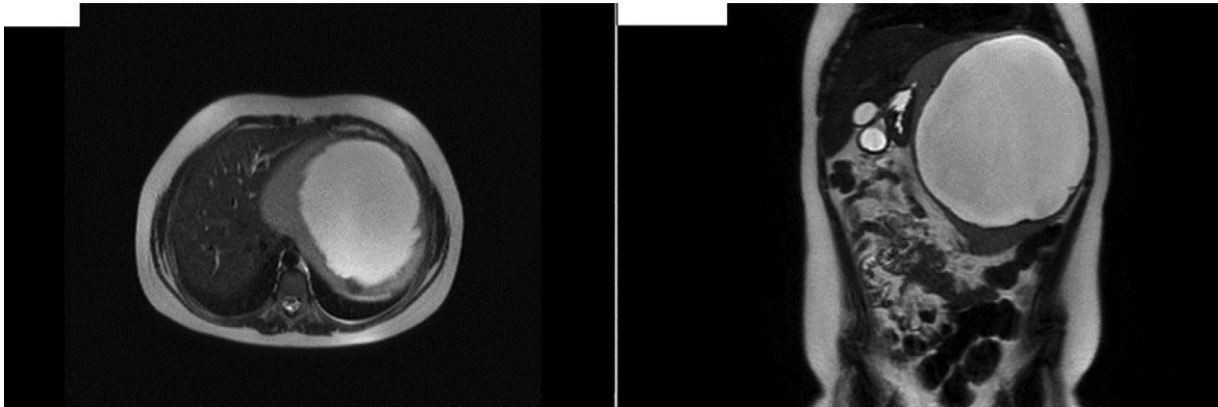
Axial (A) and coronal (B) magnetic resonance imaging of the child abdomen, showing splenomegaly ($20 \times 15 \times 16$ cm) with a polylobulated well-defined cystic mass ($16.8 \times 15 \times 15.5$ cm) with homogeneous fluid contents, hypointense T1-weighted images and hyperintense T2-weighted images without contrast enhancement.
